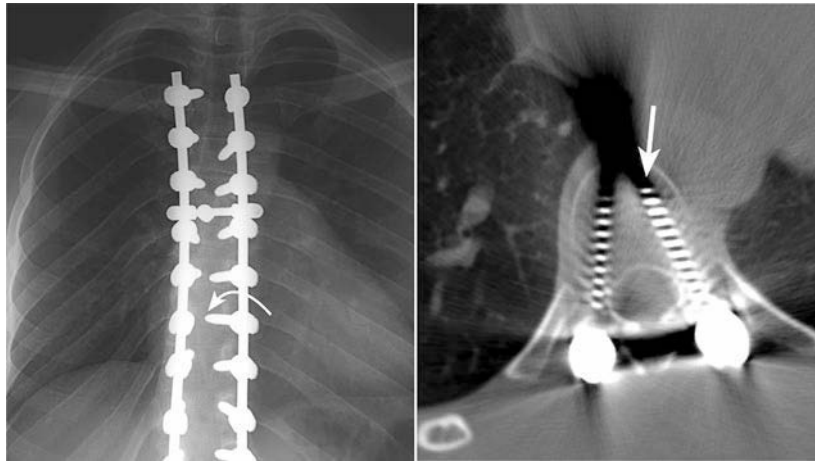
Radiographic film (left) showing a medial misplacement denoted by the arrow, with the computed tomographic scan (right) showing a normal screw placement, denoted by the arrow.
